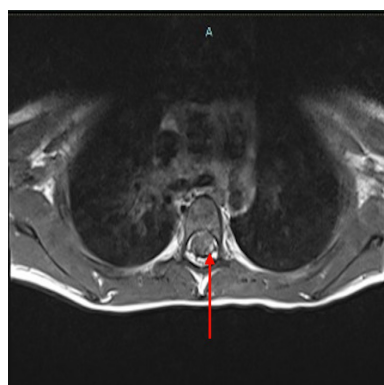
MRI Spine Axial View: Hyperintensity of the spinal cord.
